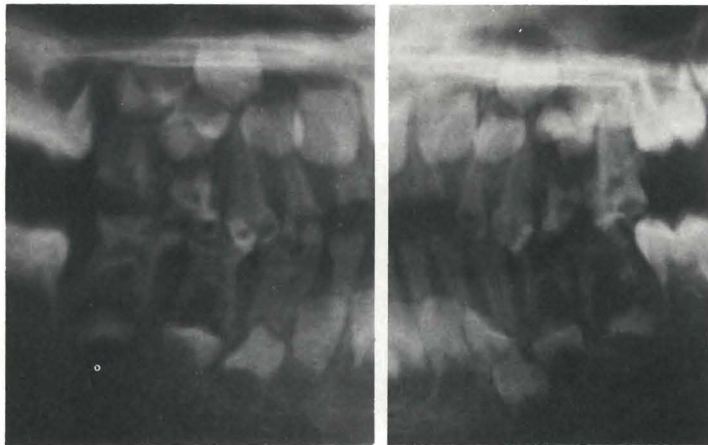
Panoramic radiograph showing nonrestorable primary molars.
